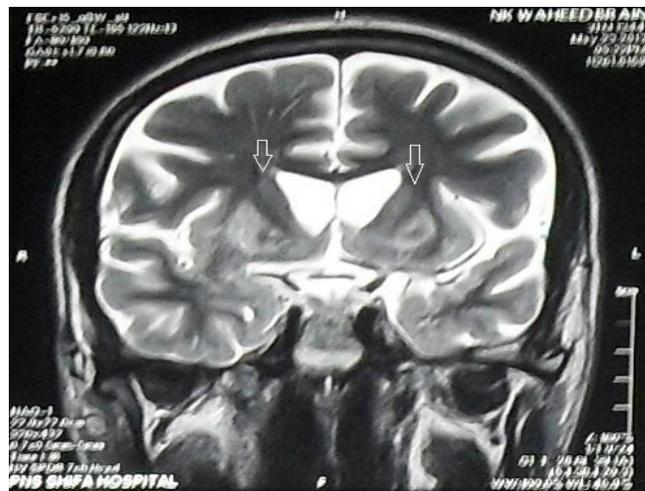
MRI brain shows hyperintense signals in caudate nuclei, lentiform nuclei, thalami and brainstem on T2 W Images and FLAIR.
